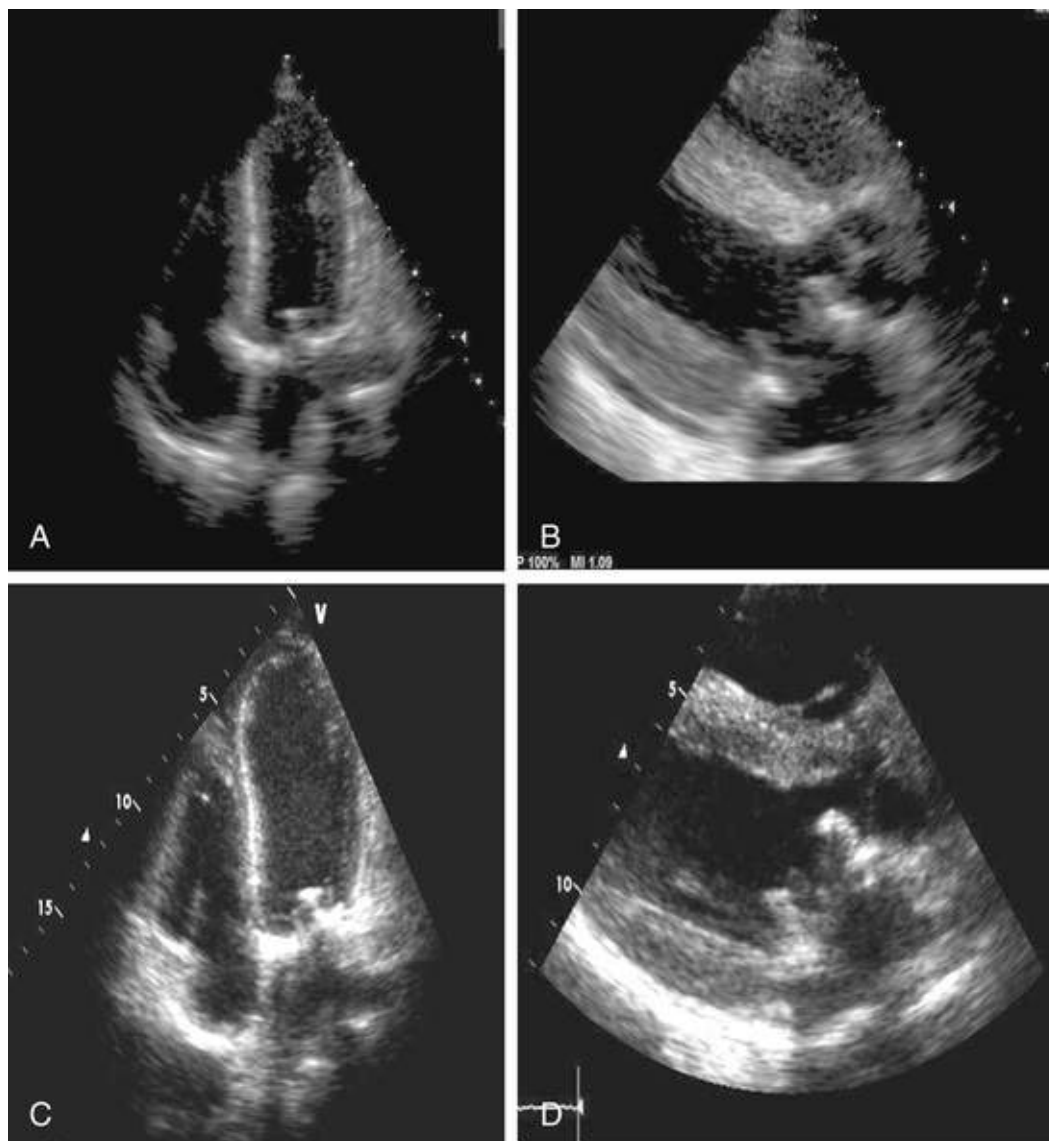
Myocarditis in systemic lupus erythematosus. A and C, Four-chamber view, B and D, Left ventricular view. In a 20-year-old patient with dyspnea and active SLE, the initial echocardiogram (A and B) showed mild impairment of ventricular function. Following symptomatic deterioration, the echocardiogram was repeated 6 days later and demonstrated markedly increased thickening of the left ventricular wall with a bright signal suggestive of inflammatory infiltration (C and D). These findings were associated with substantial deterioration in left ventricular function.
